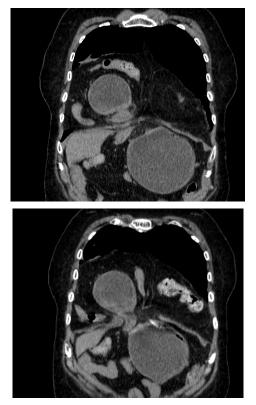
Coronal section of plain CT abdomen: Herniation of stomach, intraabdominal fat (omentum), transverse colon, and portions of the small bowel through the defect in the diaphragm.
